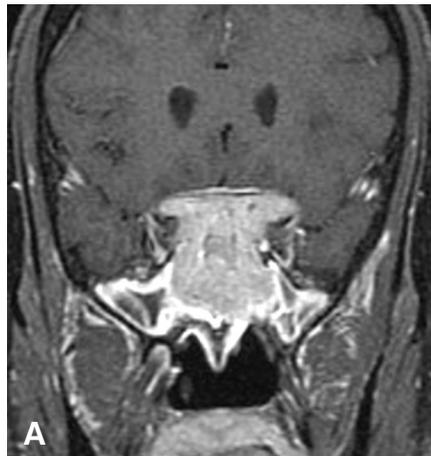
T1-weighted gadolinium-enhanced (A) coronal and (B) sagittal MR images show chiasmopathy and impressive expansion of the sella. On the sagittal MR image (B), an intracranial extension into the anterior cranial fossa resembles a dural tail.
